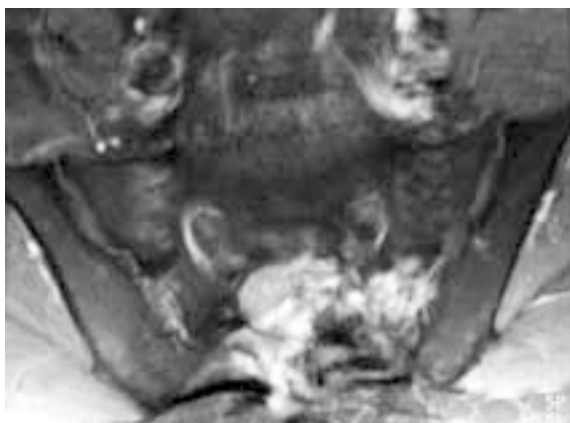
Enhanced axial T1-weighted MR image taken through the same level as Fig. 8b. Note the dense but irregular enhancement of the recurrent tumour. There is distortion of the subcutaneous tissues along the midline due to scar tissue formation from previous surgery. The patient underwent a second surgical resection of the chordoma but succumbed to widespread metastatic disease a year later.
